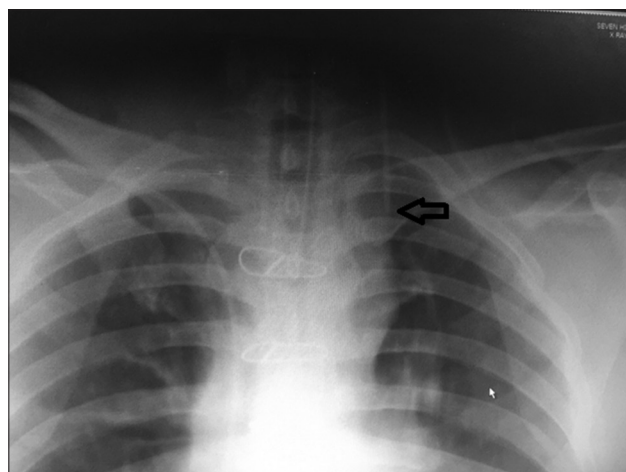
Chest X-ray showing catheter in left internal mammary vein
